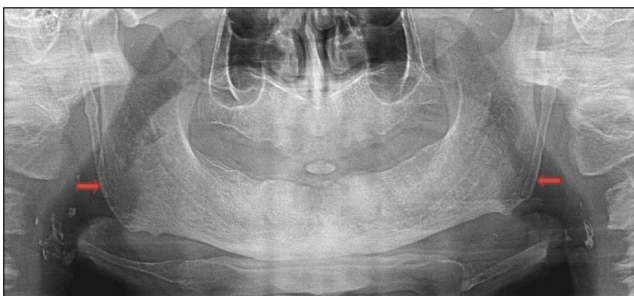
A digital panoramic radiograph showing a bilaterally elongated SP (arrows).
